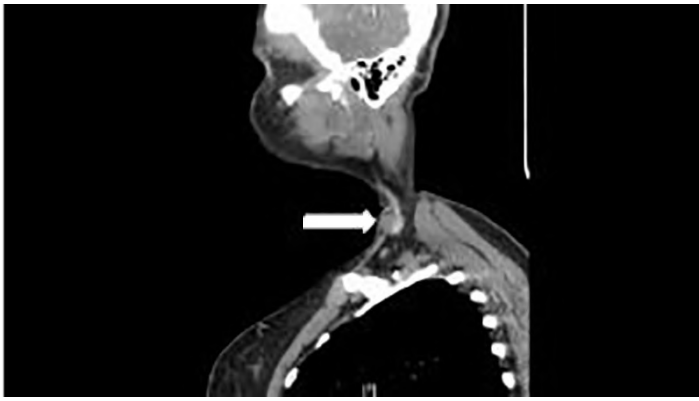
Computed tomography with contrast sagittal view of left external jugular venous pseudoaneurysm (arrow).
